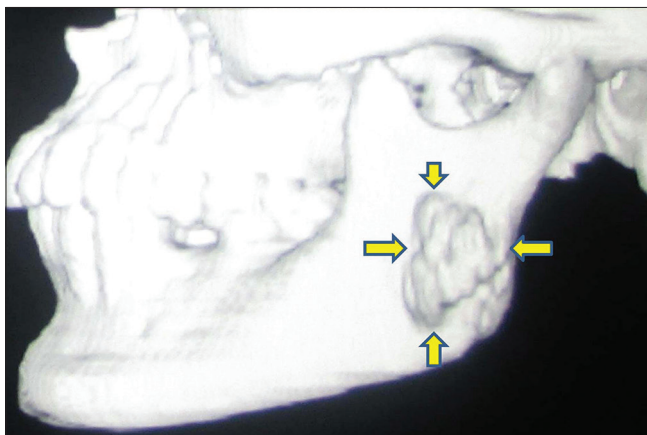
3D computed tomography scan shows destructive lesion on left angle of mandible extending in to the ramus
